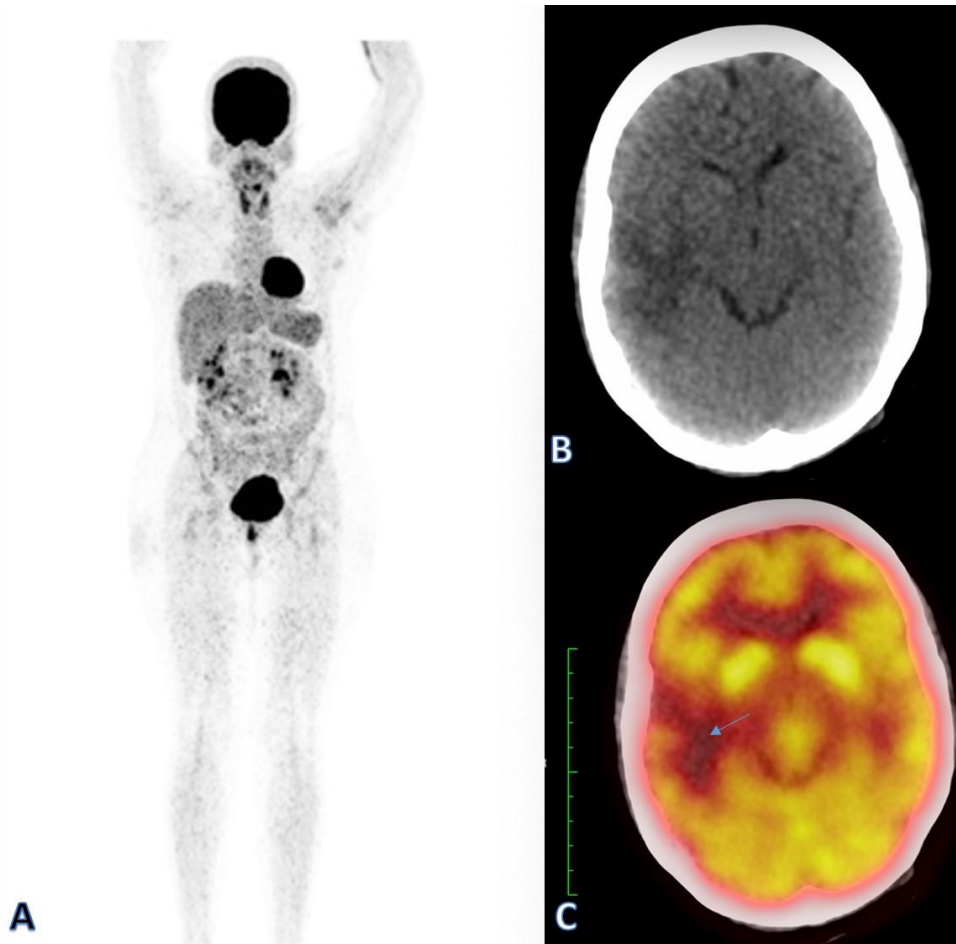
^{18}F -FDG PET/CT images showing the hypo-metabolic area (blue arrow) corresponding to the location of the lesion. No FDG avid lesions or lymph nodes were noted in rest of the study.
